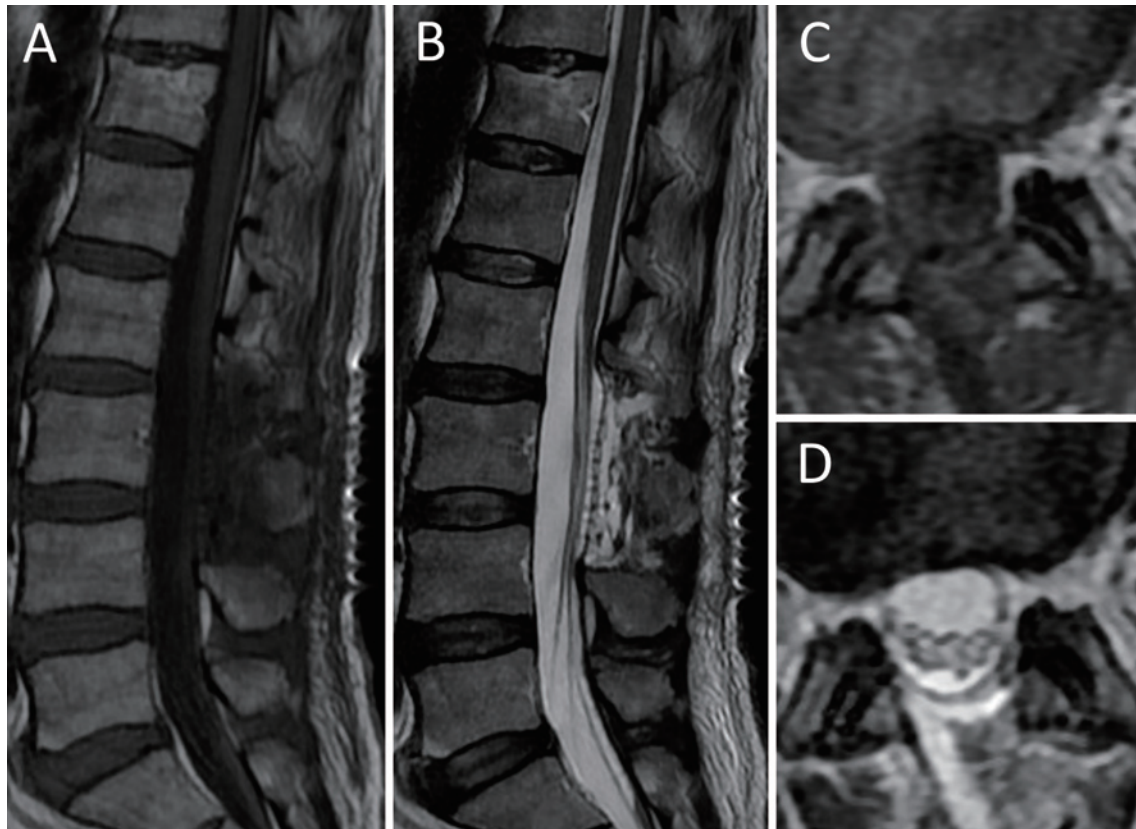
Postoperative magnetic resonance imaging of sSDH. After 4 months, no recurrence of sSDH is observed (T1: A and C, T2: B and D).
